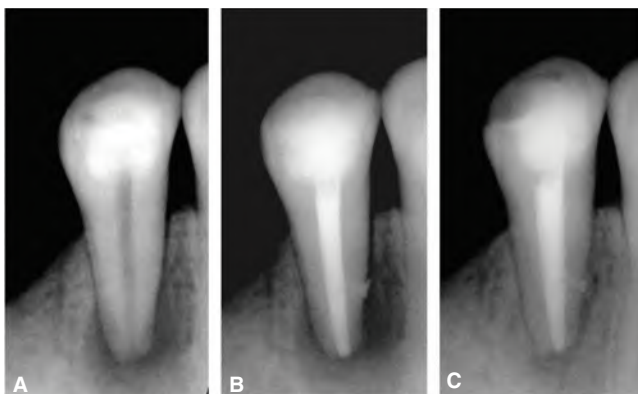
Healing of periapical lesion in a mandibular premolar of a 55-year-old male. A. Preoperative radiograph showing a large periapical radiolucency. Pulp vitality tests were negative. B. Immediate postoperative radiograph. Extrusion of sealer through a lateral portal of exit is evident (arrow). C. One-year follow-up radiograph showing active resolution of the periapical radiolucency.
